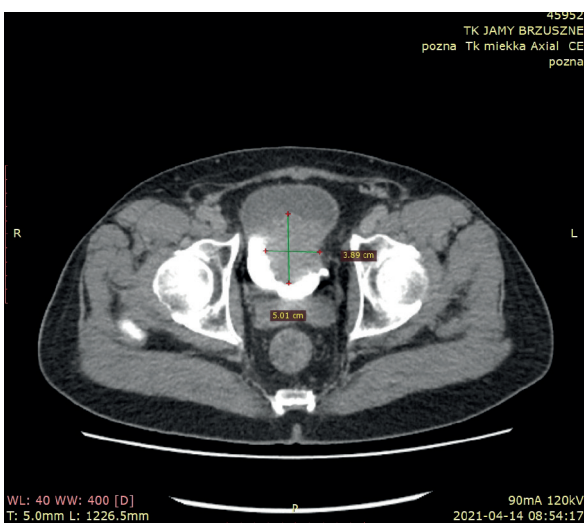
A CT scan of an extensively infiltrating 5 cm mass in the urinary bladder
